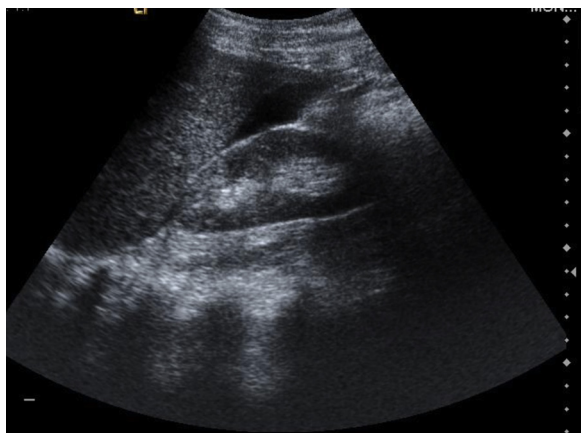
Ultrasound of Morrison's pouch revealing intraperitoneal fluid.
